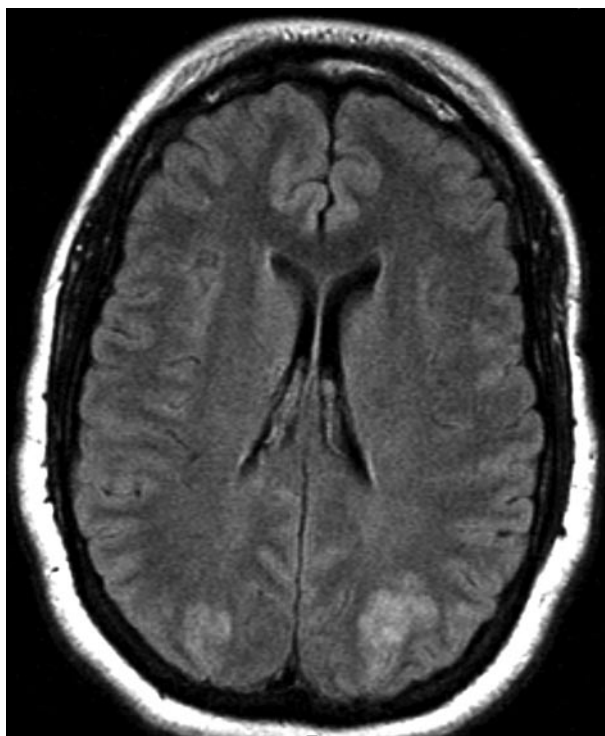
Weighted magnetic resonance image obtained following case patient 1's seizure. The image shows bilateral parieto-occipital hyperintensity consistent with posterior reversible encephalopathy syndrome.
